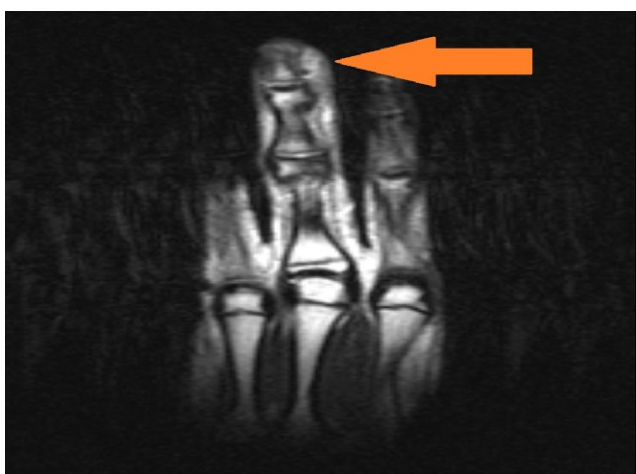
Lateral MRI scan showing extensive soft tissue edema and swelling and osteomyelitis of the distal phalanx.
